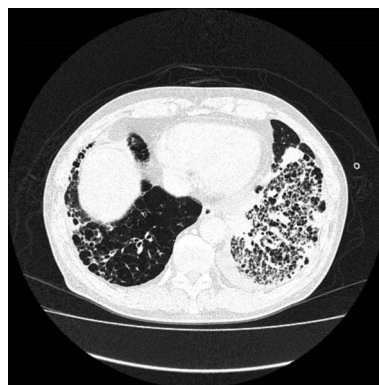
Chest computed tomography demonstrating an alveolar hemorrhage and pneumonia.
